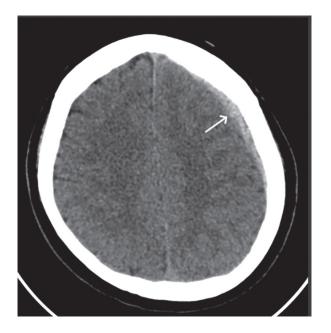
Axial cranial CT scan (brain window) shows extra-axial, crescent-shaped hyperdense lesion along the left frontoparietal convexity (arrow), compatible with acute subdural hematoma.
